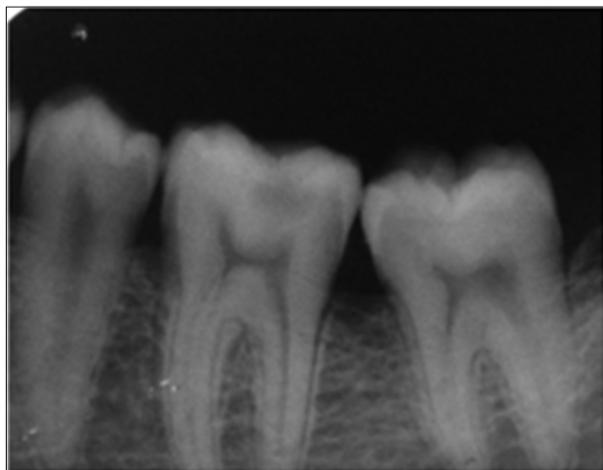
Radiographic assessment for depth of the lesion
